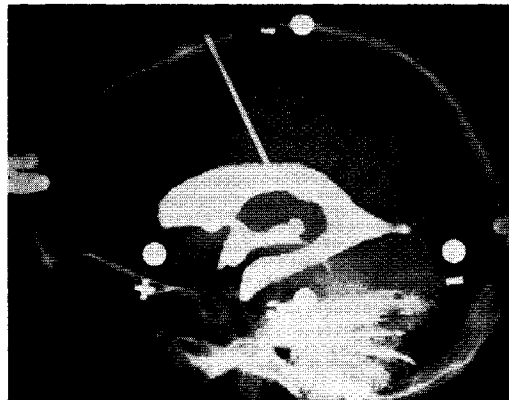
Lateral roentgenogram of human ventricular system partially filled with Pantopaque.
